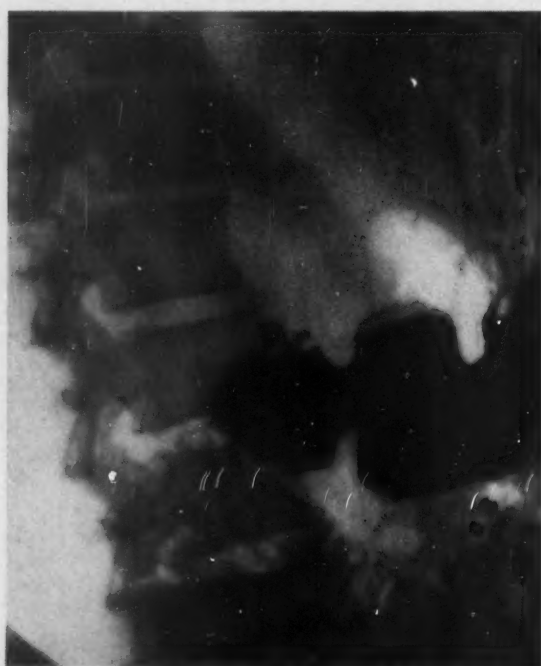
Case 3: X-Ray findings Apr. 17/52, prior to Robuden therapy. Note marked deformity and large crater of duodenum.
